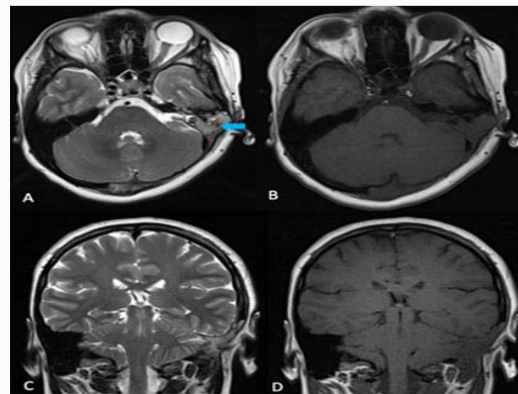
Brain MRI Axial T2WI (A) and T1WI (B); coronal T2WI (C) and T1WI (D) demonstrating continuous medullary replacement lesion, conforming to the shape of the affected bone structures, appearing as isointense on T1WI and hyperintense on T2WI with flow voids (A, arrow).
